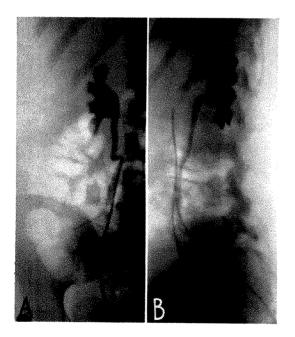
A, anteroposterior roentgenogram fails to demonstrate exact type of ureteropelvic junction lesion but suggests aberrant vessel. Kinking at tip of catheter due to catheter. B, lateral roentgenogram shows unquestionable deformity of aberrant
